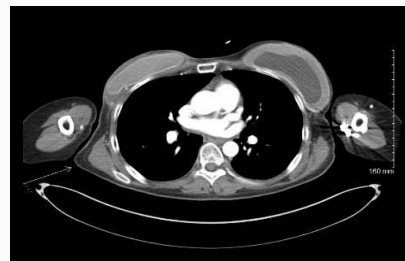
Case 1; Preoperative CTA showing perforators of the TDA.
